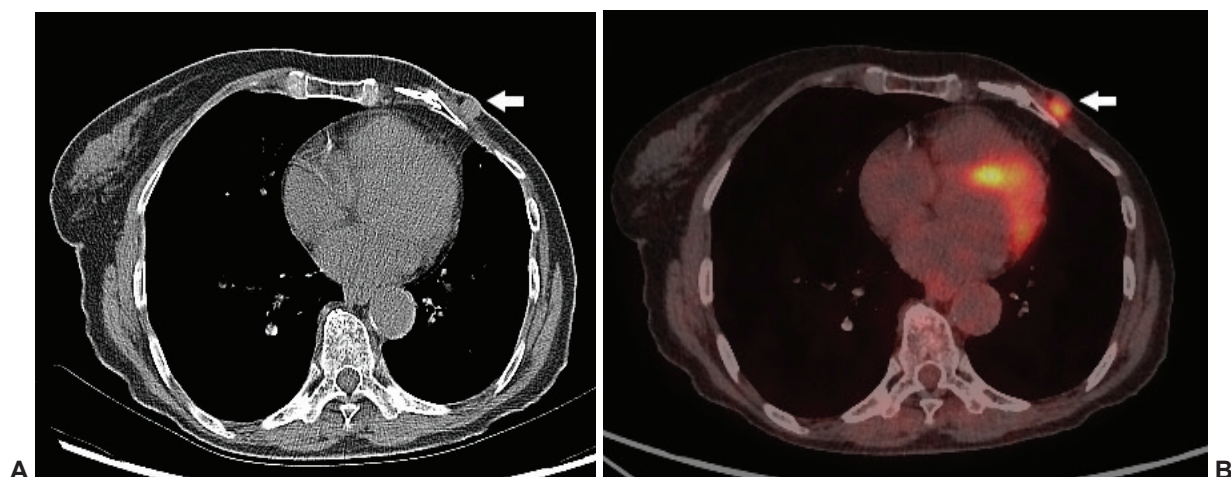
CT (A) and PET/CT (B) showing local relapse
